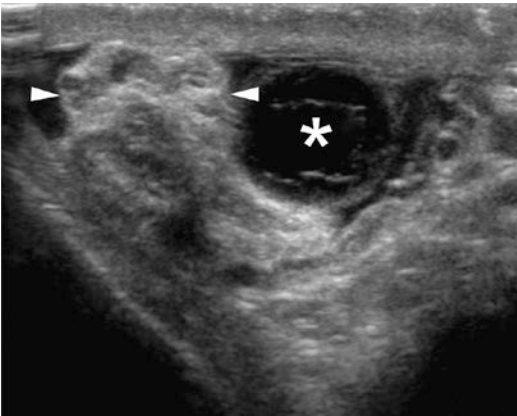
Cyst of the spermatic cord. Axial ultrasound view of the inguinal canal showing a cyst (*asterisk*) adjacent to the spermatic cord (*arrowheads*)
